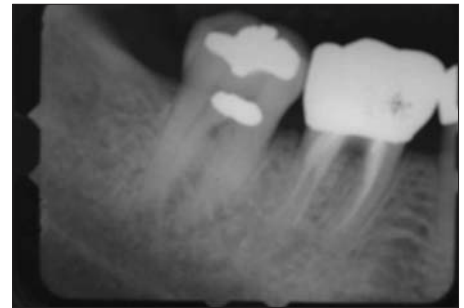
1994 periapical radiograph with radiographic furcation lesion.
